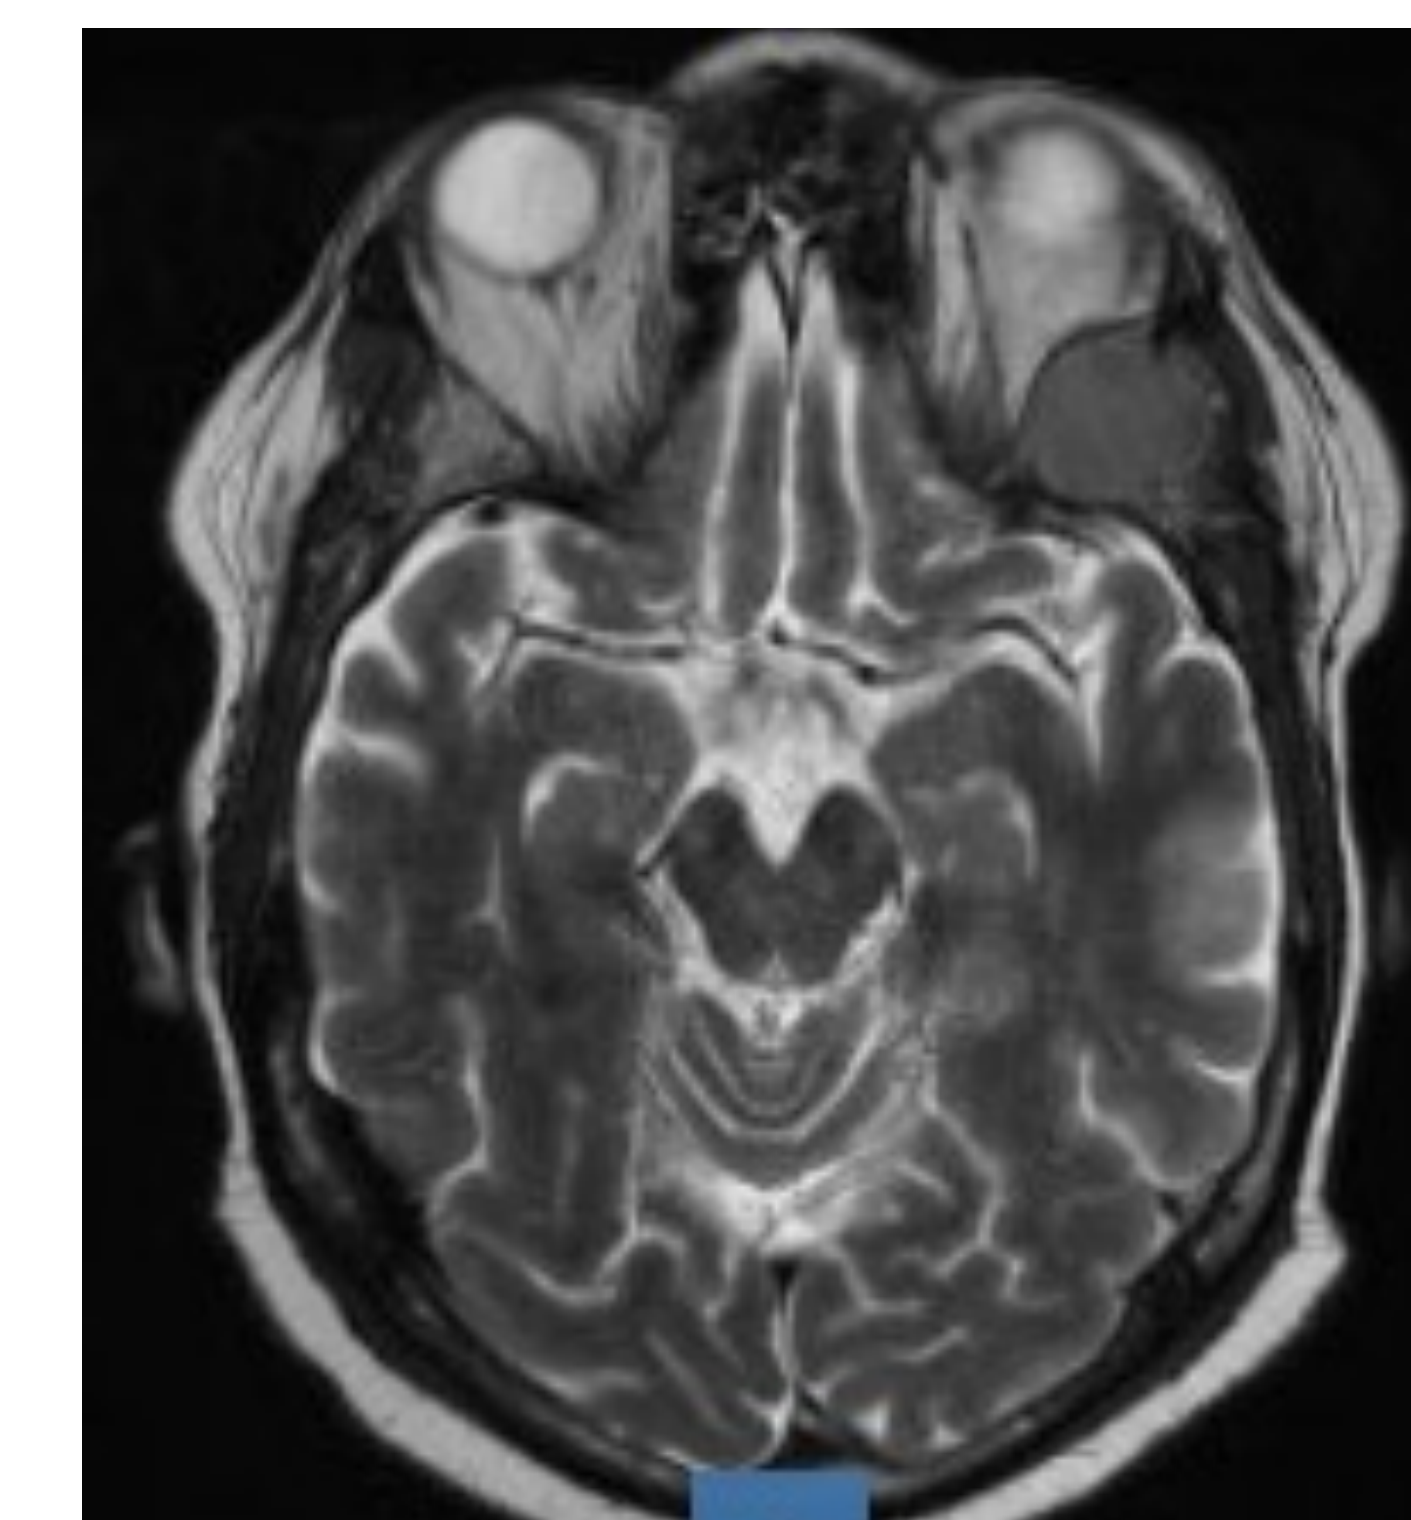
MRI brain/orbits w/w contrast: Lytic lesions throughout calvarium, skull base, and facial bones with a 3.4 cm x 2.4 cm left orbital wall mass
